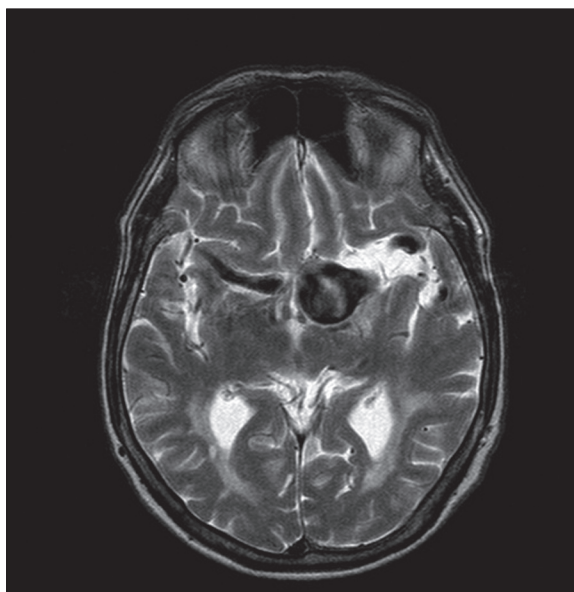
Axial contrast-enhanced T1-weighted MR image; fusiform giant aneurysm of left internal carotid artery.
